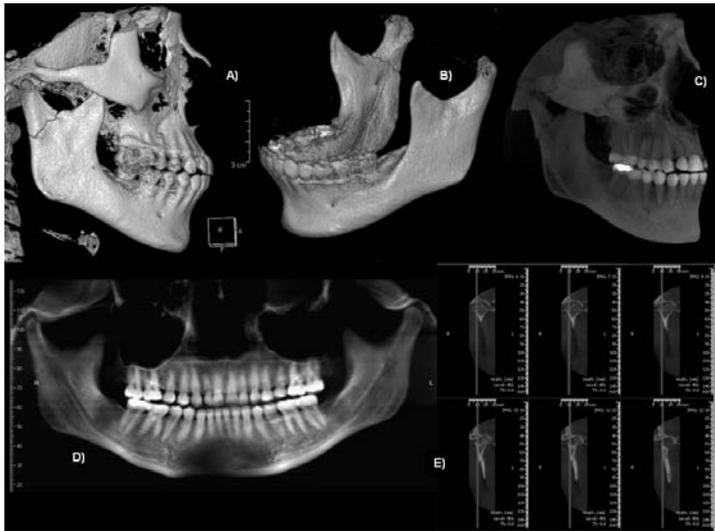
Different possible views of the TMJ complex by using CBCT. A) and B) surface mode, C) Radiographic mode, D) close up of the radiographic view, and E) cross sectional in the radiographic mode.
